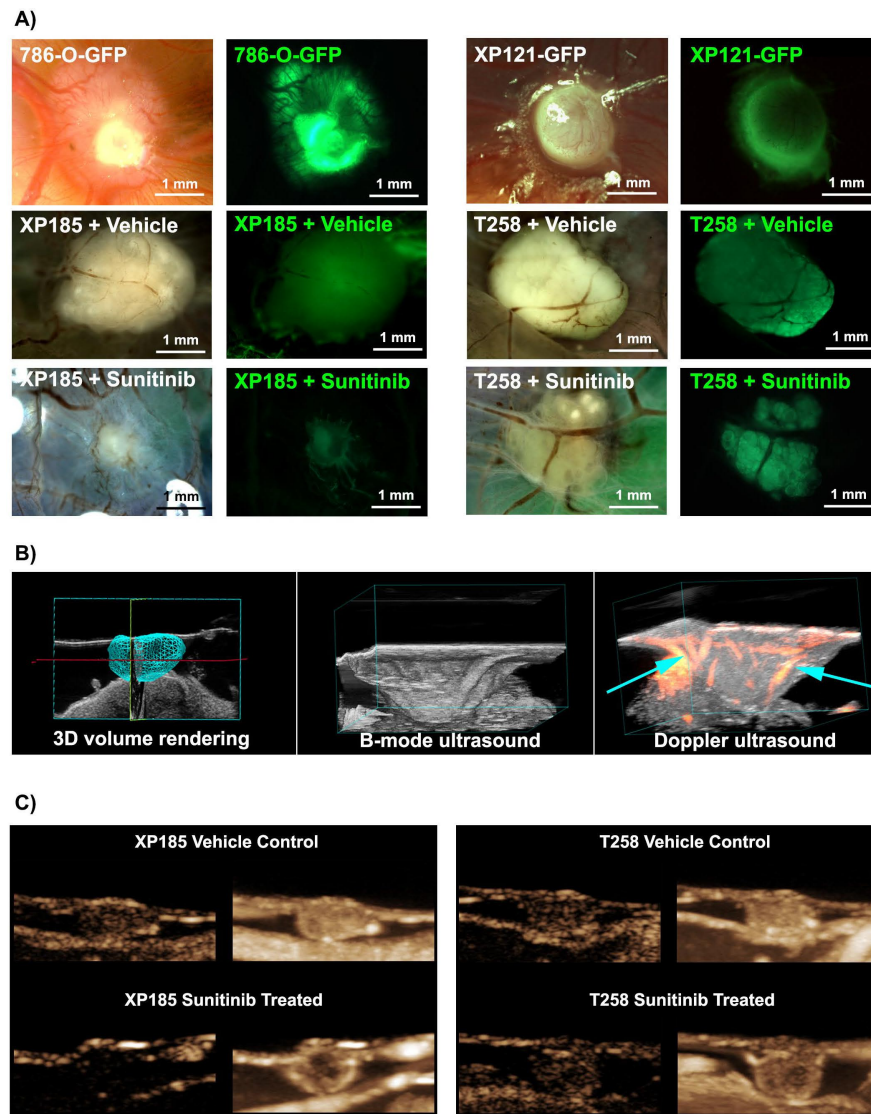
Ultrasound evaluation of intratumoral hemodynamics in RCC PDXs in the CAM. A) Tumor volume and vasculature superficially estimated when tumor cells are fluorescently labeled. Tumors generated using sunitinib sensitive cell lines (786-O and XP185) demonstrated a reduction in tumor growth and vessel formation in response to topical application of the targeted therapy. In comparison, tumors grown from resistant cell lines (XP121 and T258) did not demonstrate a treatment effect. B) When ultrasound imaging is performed, the tumor volume can be delineated (left panel), and fine structures of the tumor can be imaged when using B-mode ultrasound imaging (middle panel). When power Doppler mode ultrasound imaging is performed, areas of red blood cell movement are identified throughout the tumor and overlaid onto the B-mode image (orange-red signal, right panel). Feeding arterioles have been labeled with cyan arrows. C) Contrast enhanced ultrasound imaging confirms the presence of internal tumor vasculature. Sunitinib treated XP185 tumors demonstrated a reduction in vessel specific enhancement in comparison to vehicle control (left panel). Peripheral enhancement pattern implies lack of capillary bed in tumor core. Therapy on resistant T258 tumors did not show a trend between signal intensity and treatment group.
